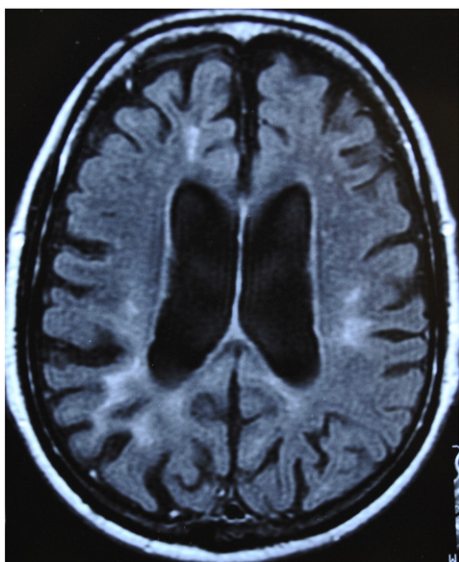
Fluid attenuation inversion recovery (FLAIR) MRI sequence showing multiple hyperintense lesions in the subcortical and periventricular white matter with no mass effect.
